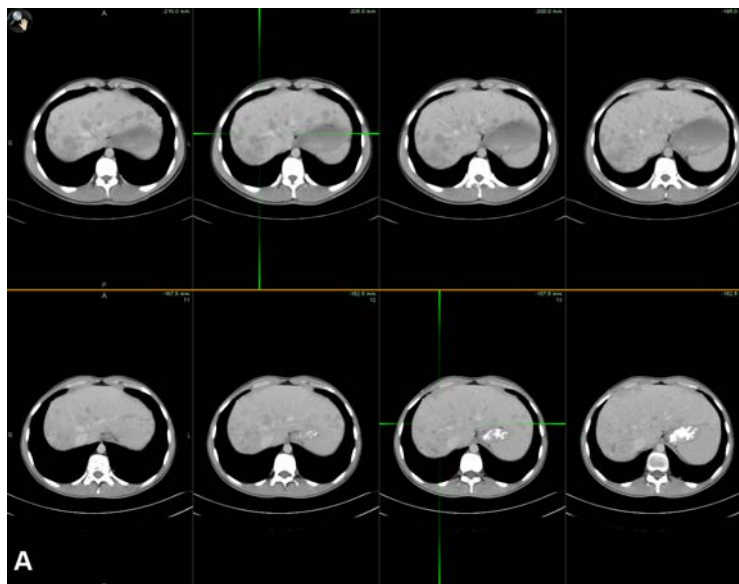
Abdominal CT scan before (top row) and 3 months (bottom row) after SIRT, showed partial response in a 21-year-old male patient with multiple metastatic liver lesions from carcinoid tumor (case N° 3)
